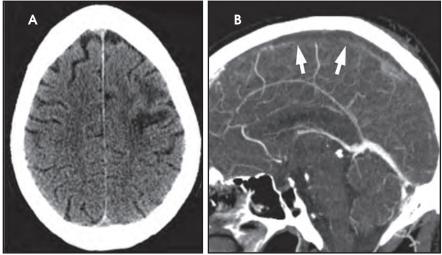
48-year-old man with headache developing over a period of 1 week. (A) Unenhanced axial CT image shows a focal region of subcortical hypodensity region in the left hemisphere with sparing of the overlying cortex. This pattern may mimic vasogenic edema, but can also be seen with ischemia due to venous sinus thrombosis. (B) Sagittal maximum intensity projection image from CT venogram confirms the presence of thrombus within the superior sagittal sinus (arrows).
